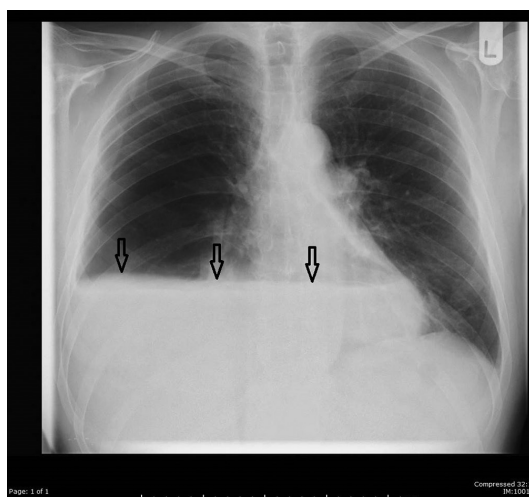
Chest X-ray. Arrows mark the air fluid level in the stomach.
